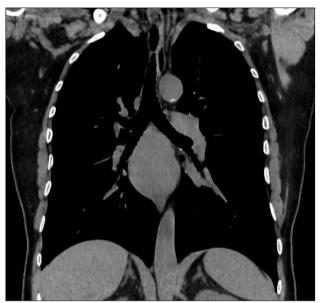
Coronal CT section before injection of contrast product showing a water opacity pushing the left ear and the right lower pulmonary vein forward.
